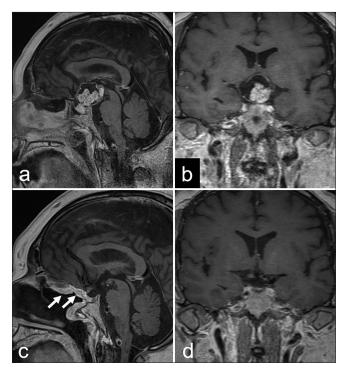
(a) Contrast-enhanced sagittaland (b) coronal magnetic resonance imaging (MRI) scans obtained before the endoscopic endonasal approach (EEA), showing the heterogeneously enhancing suprasellar mass with optic chiasma compression. The post-EEA MRI scan shows (c and d) gross total tumour resection with decompression of the optic apparatus and complete reconstruction of the skull base using a well-enhanced pedicled nasoseptal flap (arrow).
